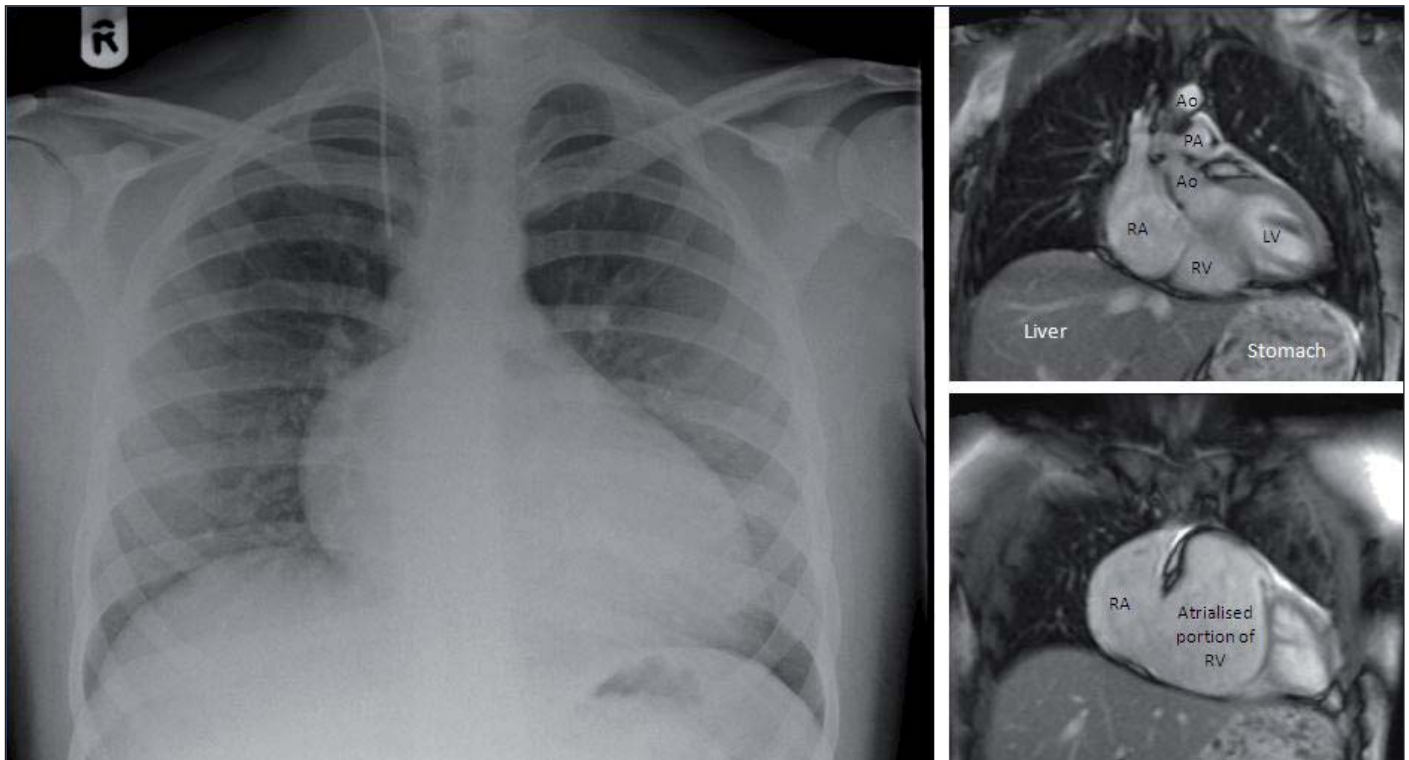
Chest radiograph and corresponding coronal magnetic resonance images demonstrating the cause of the enlarged cardiac silhouette. Ao= aorta; LV=left ventricle; PA= pulmonary artery; RA= right atrium; RV= right ventricle.
